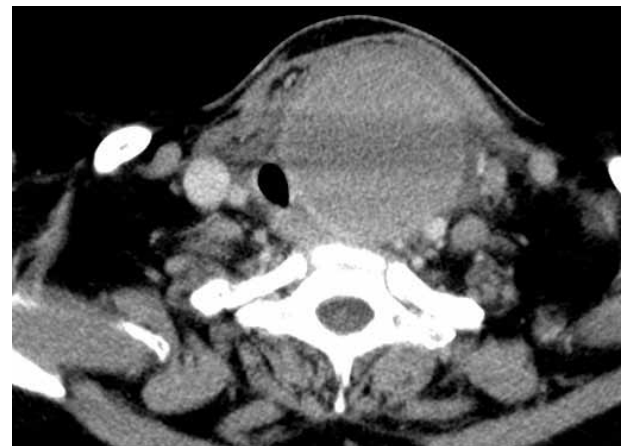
CT image of the neck shows a rim-enhancing cystic lesion arising from the left lobe of the thyroid.
